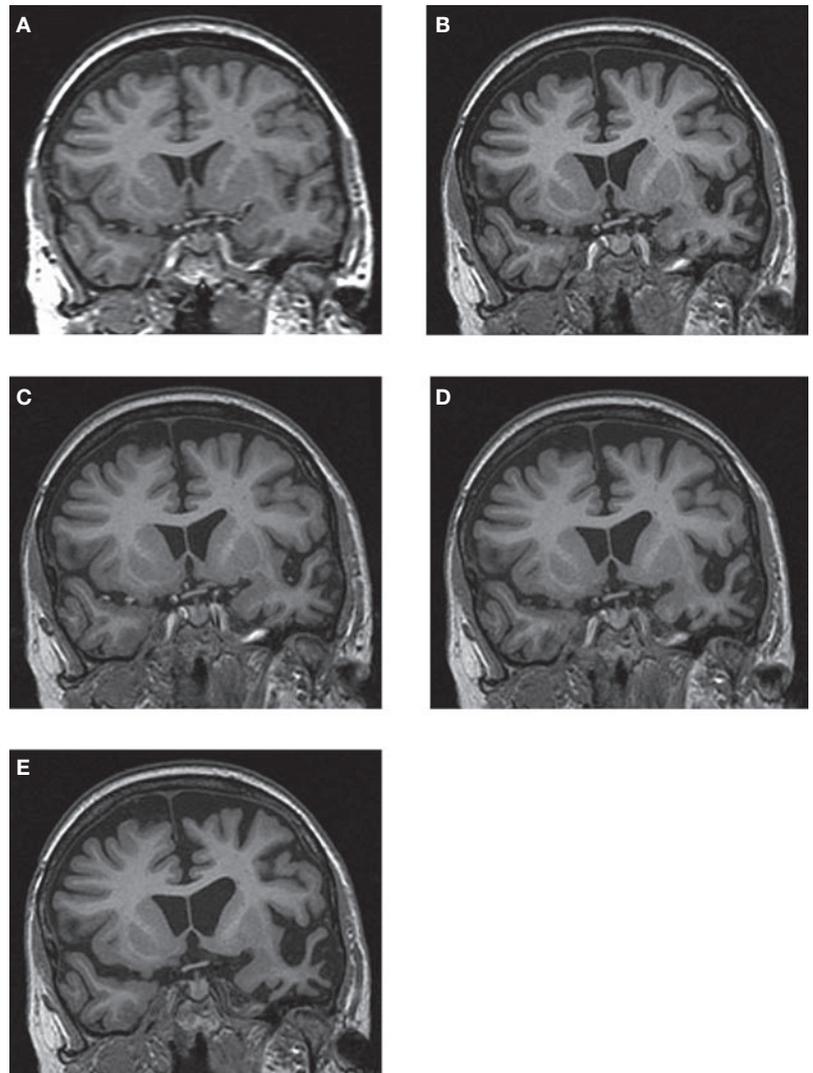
Series of five registered T1-weighted MRI scans of a patient with progranulin-associated frontotemporal lobar degeneration. (A) MRI scan 8.5 years before symptom onset. (B) MRI scan 18 months before symptom onset. (C) MRI scan 6 months before symptom onset. (D) MRI scan 6 months after symptom onset. (E) MRI scan 18 months after symptom onset.
